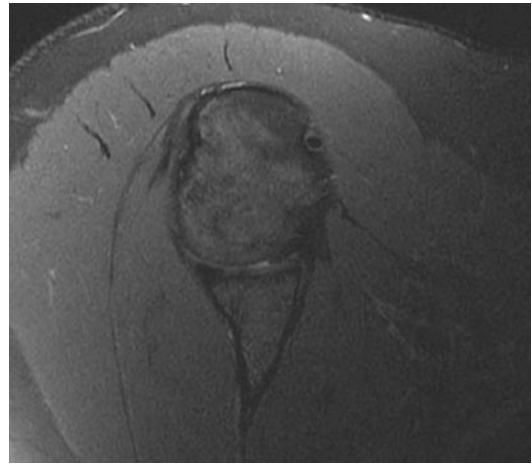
More distal axial T2 MRI image portraying subtle anterior glenoid bone loss and anterior labral tear
